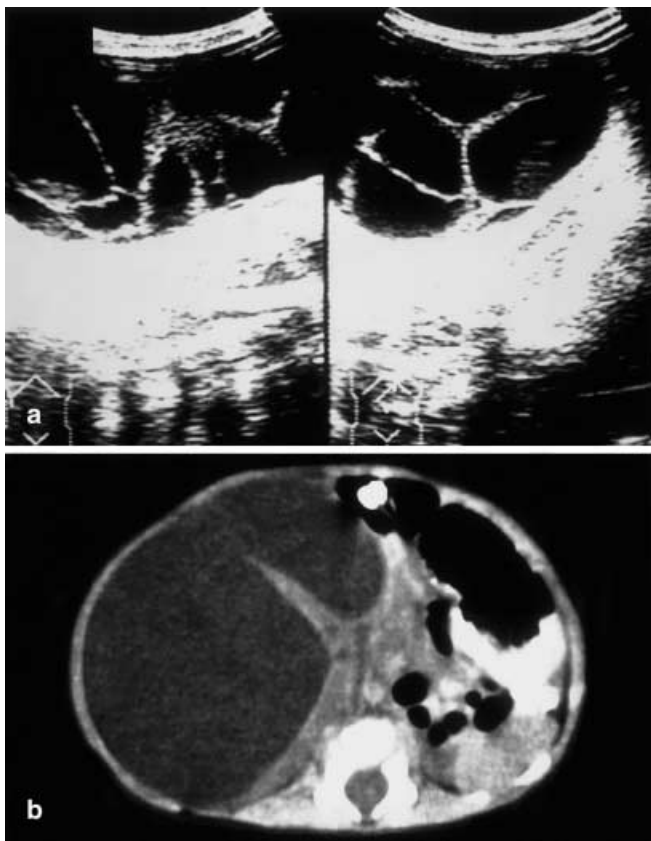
a Longitudinal ultrasound scan of the urinoma. Multiple septa are present in the collected fluid. b On the computed tomographic scan, the urinoma looked like a giant single cyst, because respiration interfered with the detection of the thin septa
